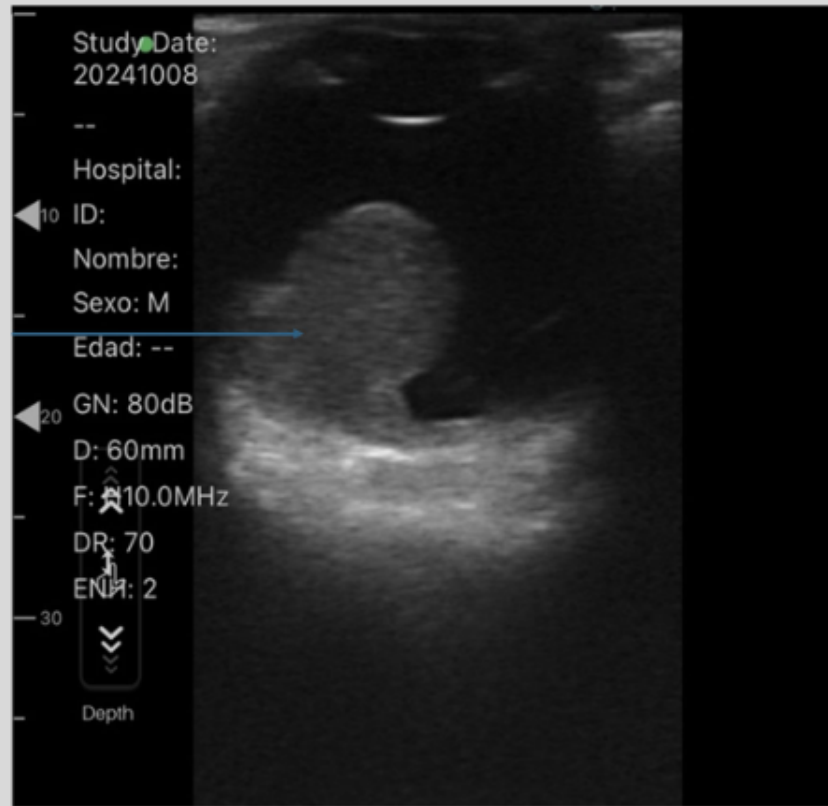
Ocular point of care ultrasound (POCUS) of the right eye. The blue arrow points to a space-occupying lesion in the right globe.
